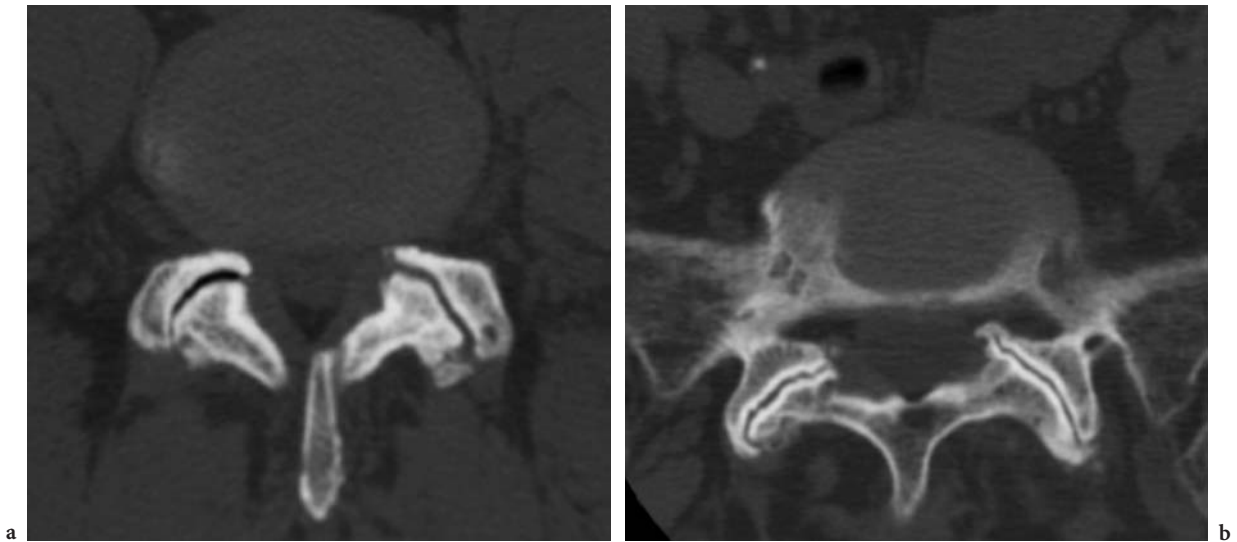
Facet joint subluxation due to the sagittal orientation of the facet joints. Axial (a) and sagittal reformatted CT (b). Axial CT shows loss of the normal coincidence of the facet joints (a). This is the result of the sagittal orientation of the facet joints and associated retrolisthesis L2–L3 can be observed (b)
